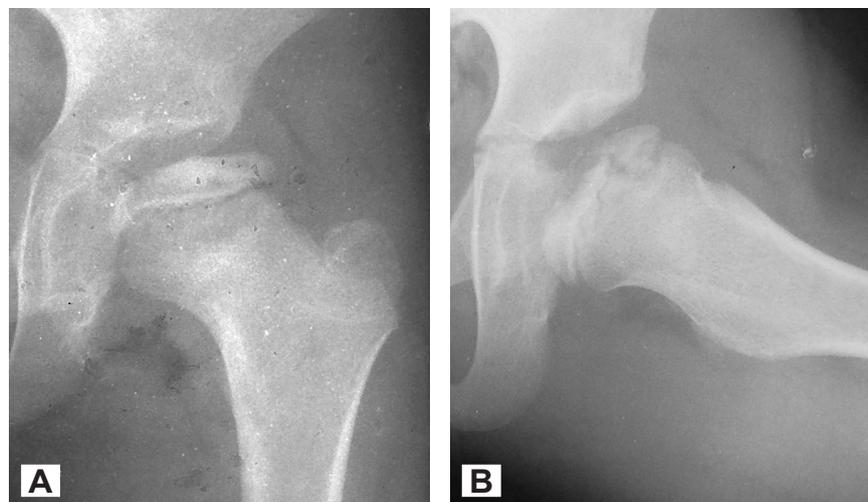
X-ray of left hip joint A – front plane, impression and total involvement femoral head, and B – frog-leg position. Anterior part of femoral head is preserve, while posterior is impressed and has ephyphisional cyst
